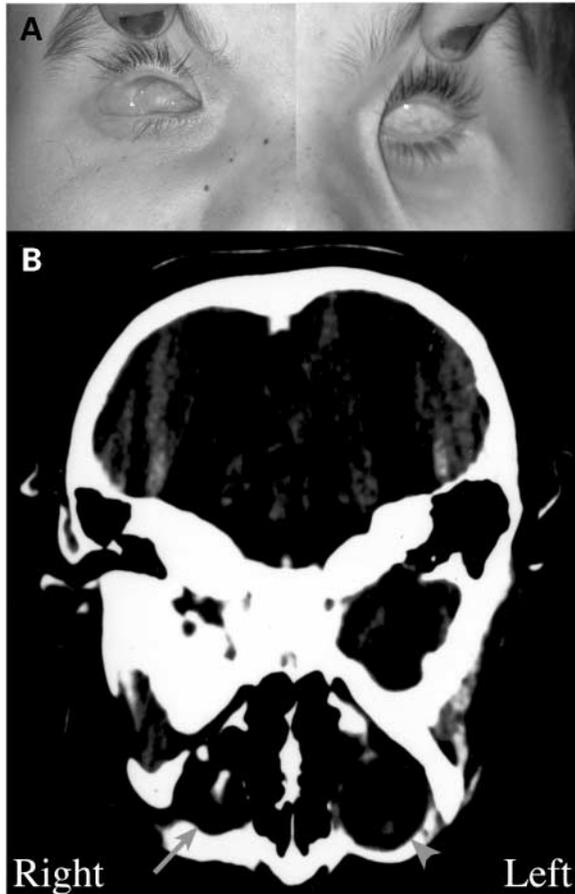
Ocular phenotype of proband. (A) Orbits of proband, showing absence of ocular tissue OD (his right) and sclerocornea OS (his left). Note that the tissue seen in the right orbit is a dermal fat graft placed at 2 years of age. (B) CT scan of proband showing anophthalmic orbit (gray arrow) and other orbit (gray arrowhead). Note that the plane of the scan suggests bony defects that are not present in the patient.
